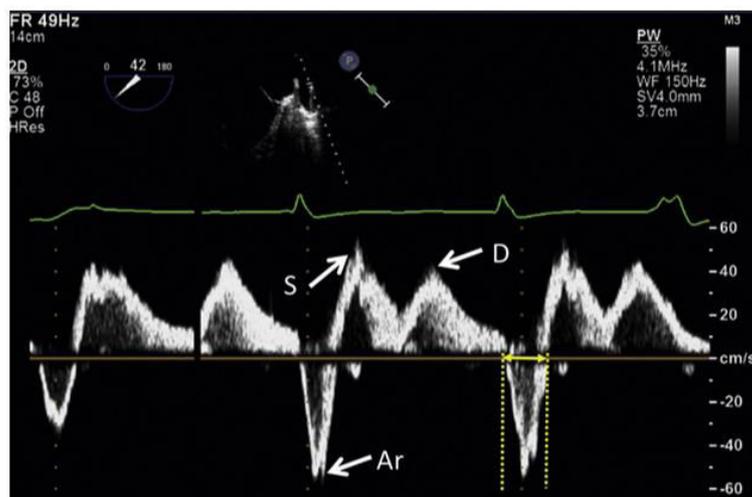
The different waves of a pulmonary vein Doppler
